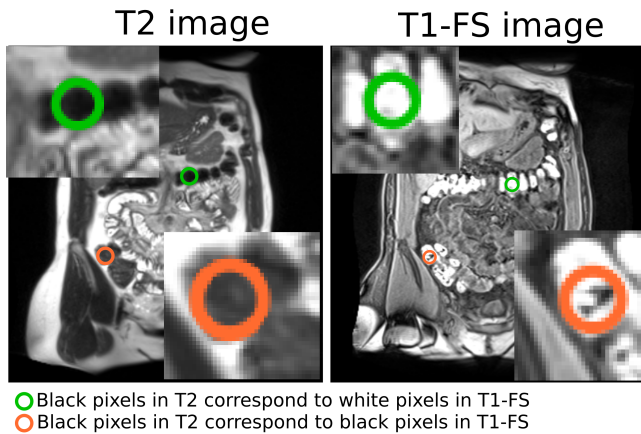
Differences between T1-FS and T2 MRI modalities for the same abdomen region. Black pixels in T2 (left) may correspond to gas (orange circle) or stool (green circle) in T1-FS images (right).
